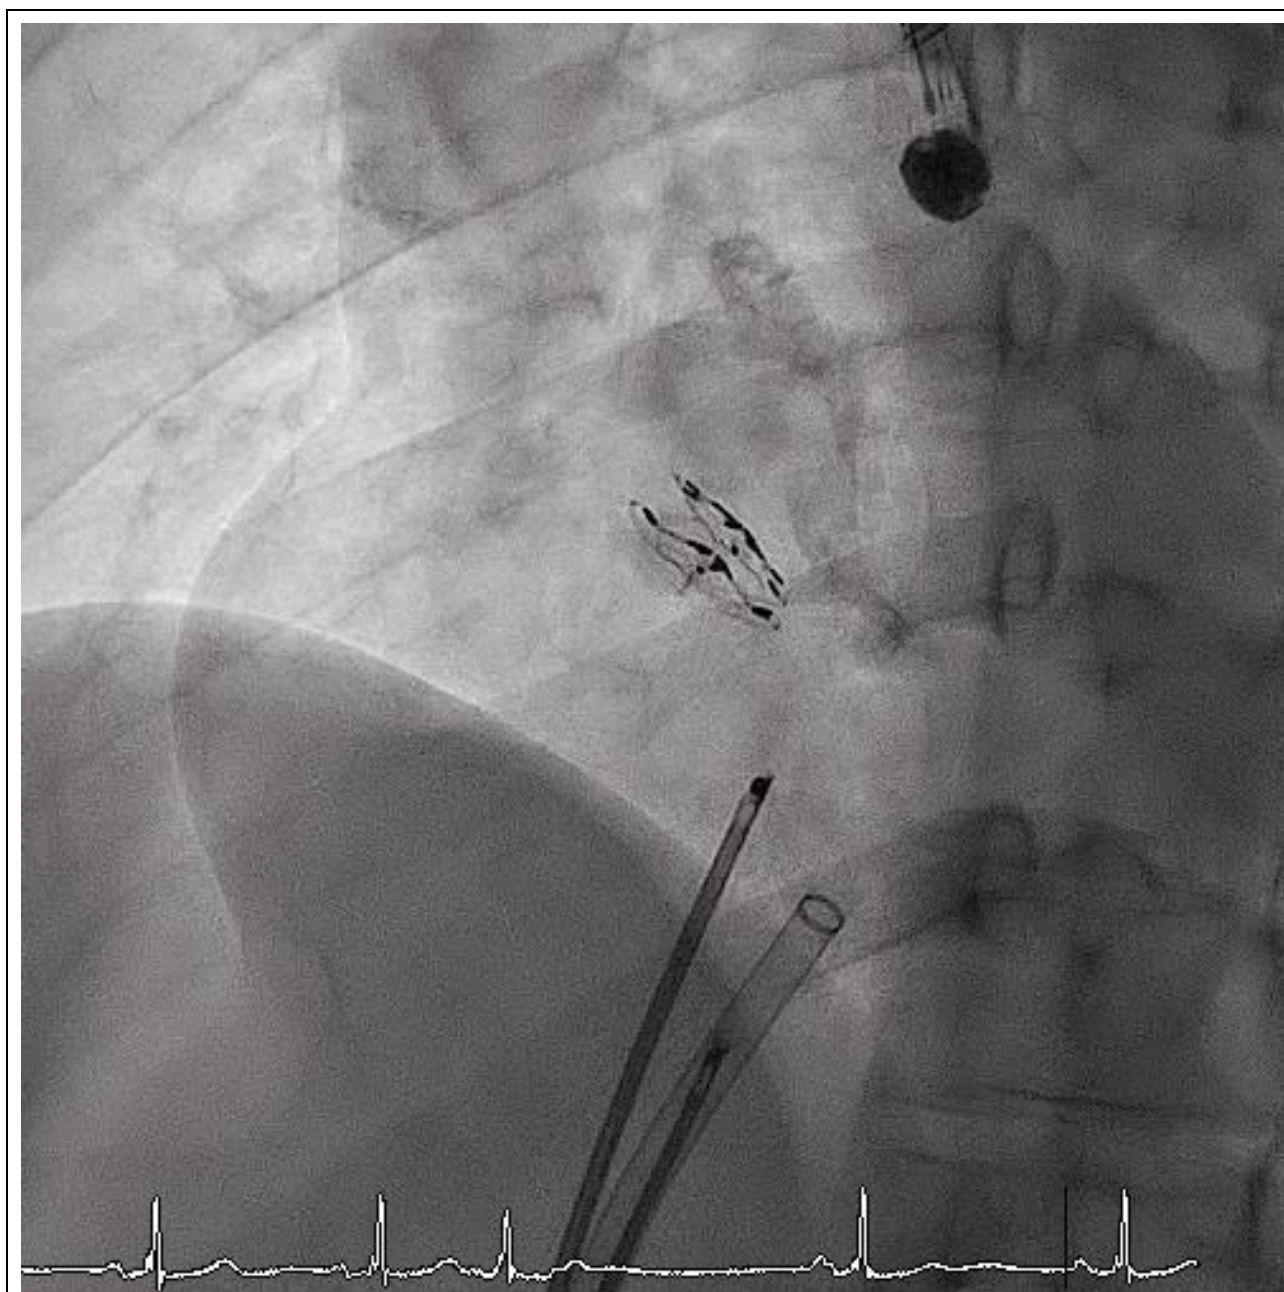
Device and calcification in X-ray.
